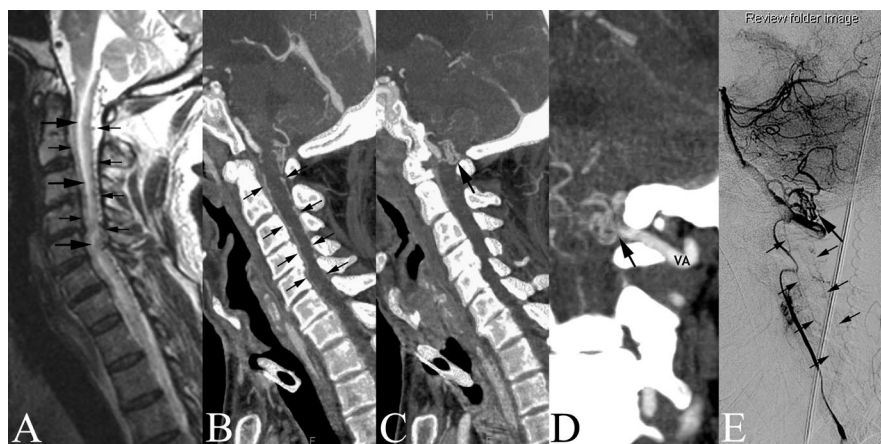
(A) T2-weighted sagittal MRI shows hyperintense cervical cord (large arrows) and perimedullary vessels (small arrows). (B) Sagittal multi-detector row computed tomographic (MDCT) angiography shows the perimedullary veins (small arrows). (C) Sagittal and (D) coronal MDCT angiography reveal the fistula (arrow) at foramen magnum, fed by a dural branch of left vertebral artery (VA). (E) Catheter angiography of the left vertebral artery shows similar depiction of MDCT angiography.
